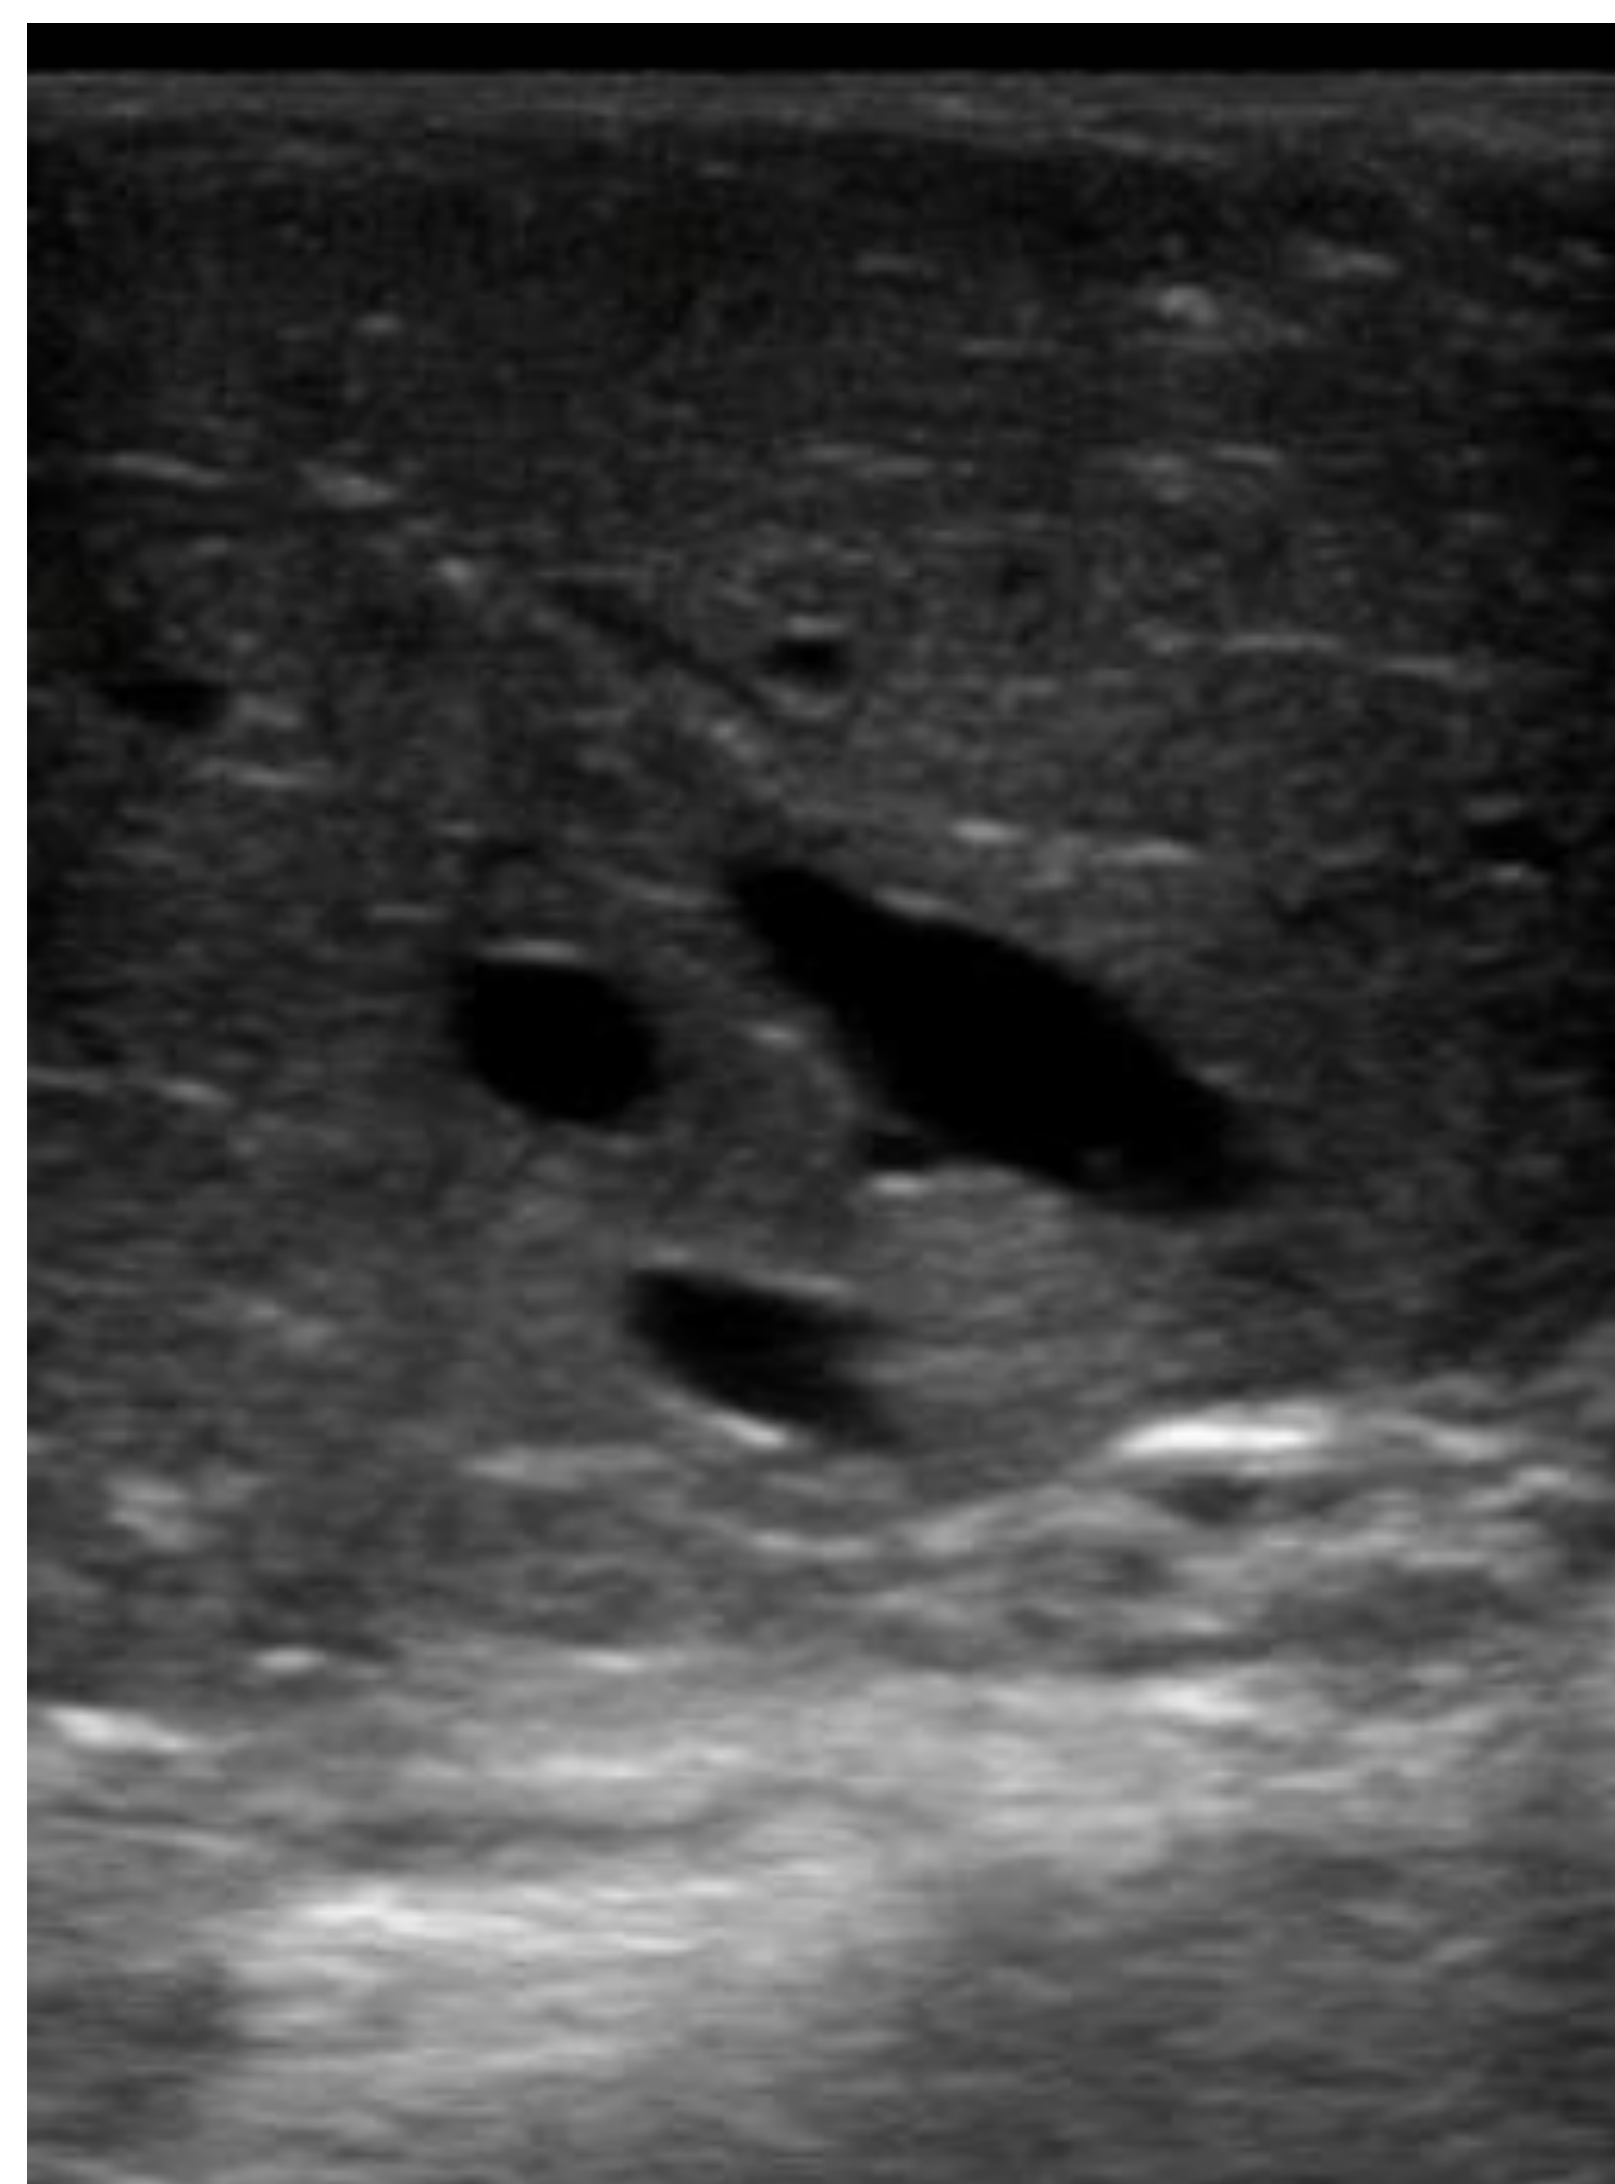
Ultrasound image of mass with glandular structure
